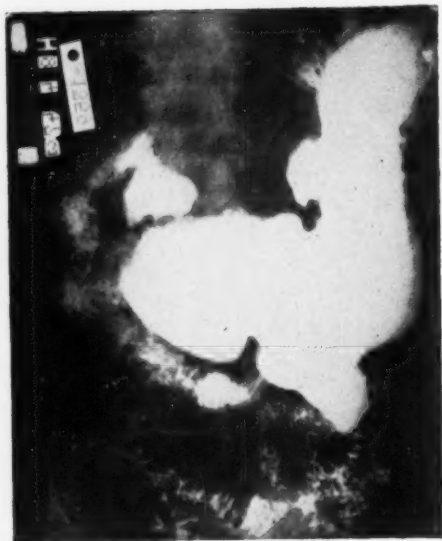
Roentgenogram showing large irregular crater on lesser curvature pars media.
